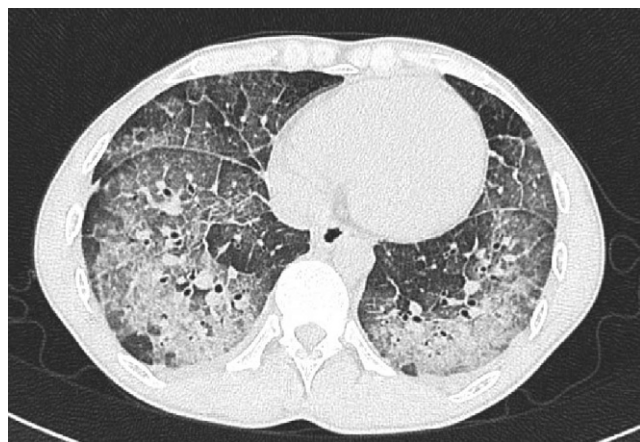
Chest CT demonstrated diffuse ground glass opacities, reticular shadows, and alveolar septal thickening.
